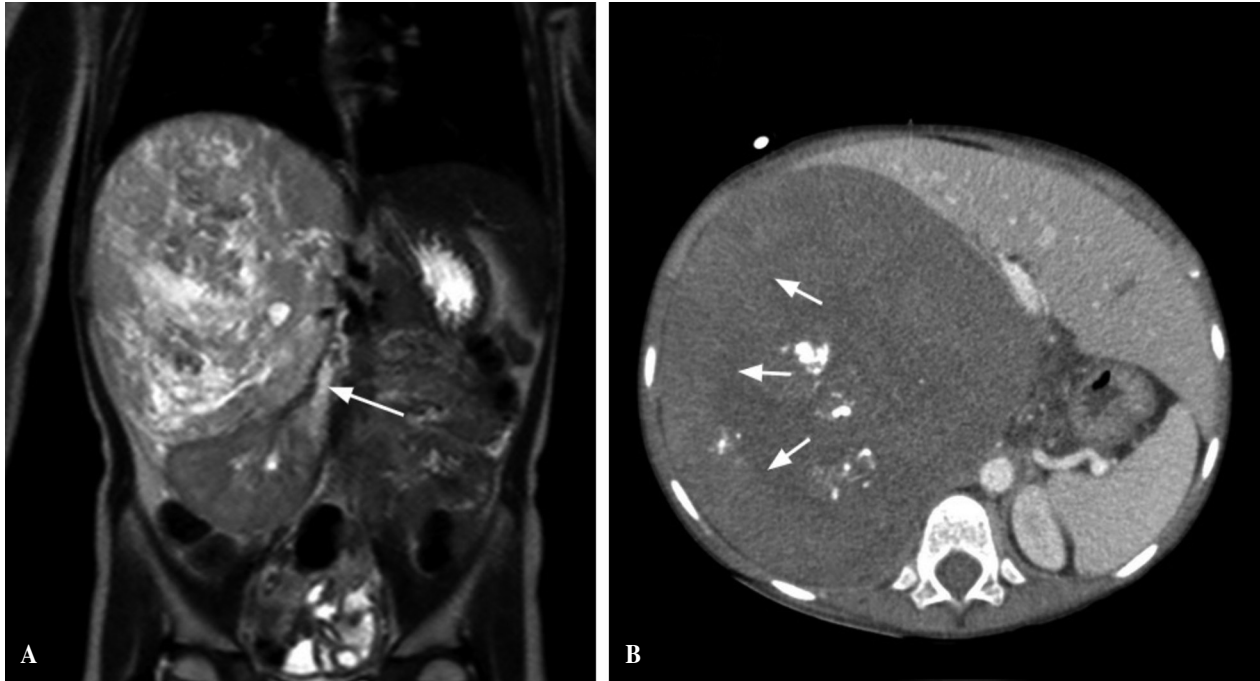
A) Coronal T2- enhanced abdominal MRI at diagnosis. An heterogeneous well defined large right adrenal lesion is seen, with necro-cystic areas and calcifications. There is a secondary mass-effect displacement of the liver and the ipsilateral kidney, which are pushed posteriorly and caudally, respectively. The lesion is in contact with the right renal vein, but no infiltration is seen (white arrow). B) Axial abdominal CT scan with contrast one month later. There is an increase in the size of the adrenal mass, maintaining the necro-cystic areas seen previously. A newly viewed shape-moon hyperdense image is seen on the lateral border of the mass (white arrow), which could be associated with internal bleeding.
